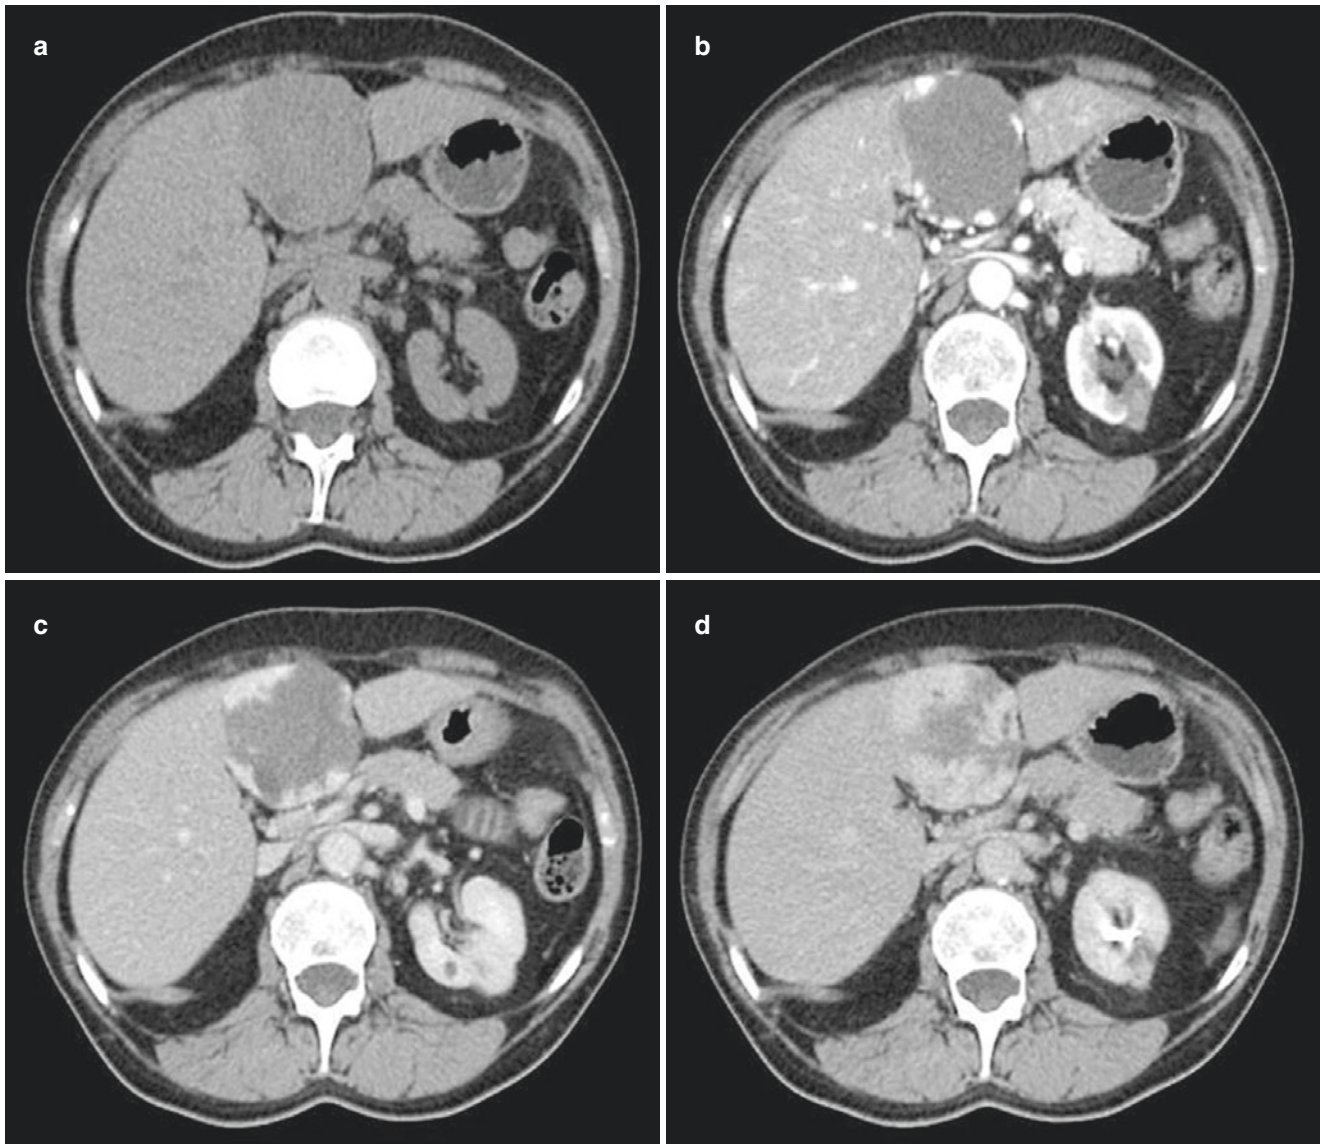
(a–d) Cavernous haemangioma in the left hepatic lobe. Unenhanced CT scan (a) shows a 7-cm-in-size lesion with smooth margins that is slightly hypodense respect to the surrounding parenchyma.
